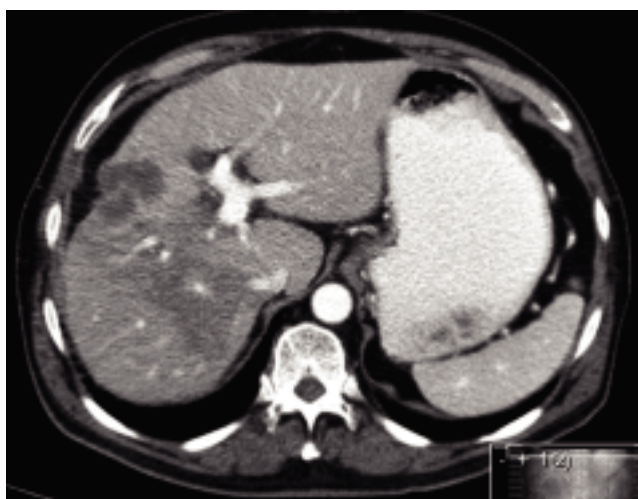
Six weeks follow-up CT image, showing stable disease according to the RECIST 1.1 criteria.
